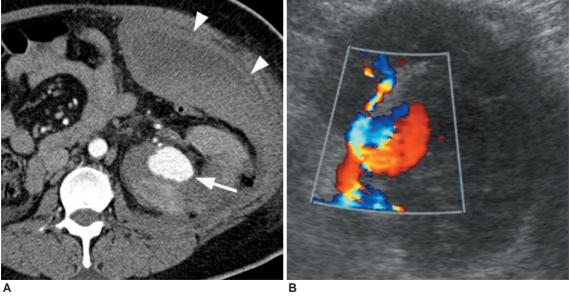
A. Transverse CT image of the arterial phase shows a collection of contrast medium (arrow) near the renal sinus of the left kidney that is compatible with a pseudoaneurysm. A large intraperitoneal hematoma (arrowheads) is noted along the left anterior abdominal wall.
